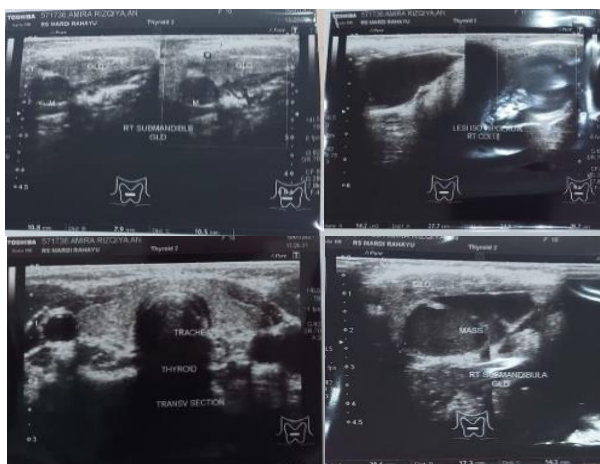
Ultrasound radiographic examination
